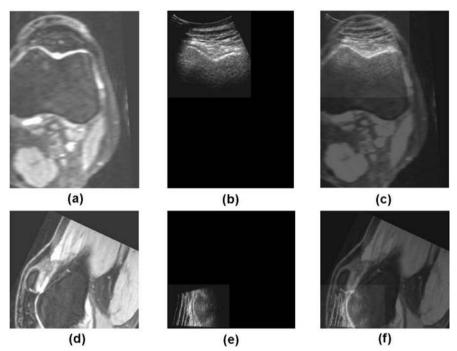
Ultrasound-MR registration results (a) axial MR slice (b) corresponding axial ultrasound slice (c) axial MR-ultrasound fusion image (d) sagittal MR slice (e) corresponding sagittal ultrasound slice (f) sagittal MR-ultrasound fusion image.
